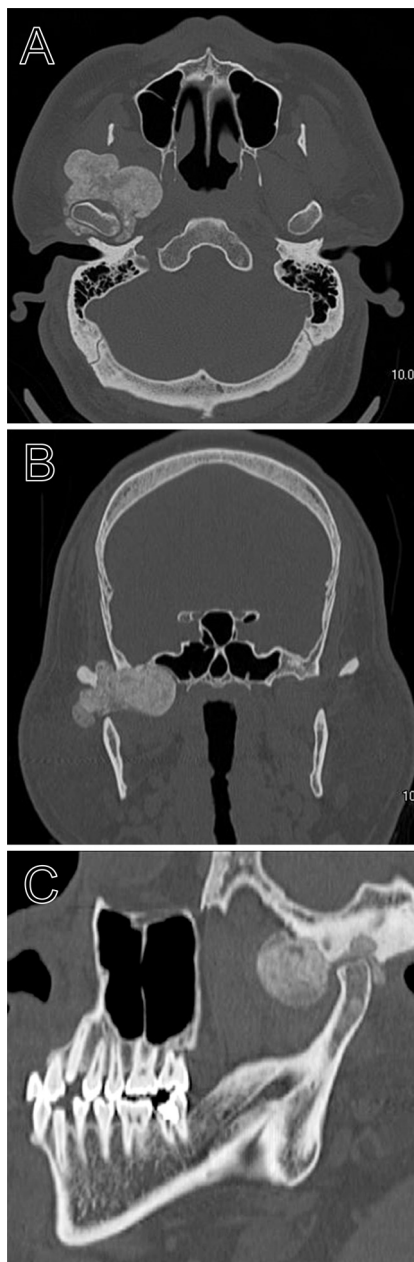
Computed tomography (CT) imaging showing a large calcified mass around the right temporomandibular joint (TMJ). (A) Axial CT scan showing a ring-shaped calcified mass around the condylar process of the right TMJ; the mass is not continuous with the mandibular condyle. (B) Coronal CT scan revealing a calcified mass in the joint space; bone resorption and thinning of the middle cranial base are present and the lesion appears to extend into the middle cranial fossa. (C) Sagittal CT scan of the right TMJ; the calcified mass limits condylar head movement.
